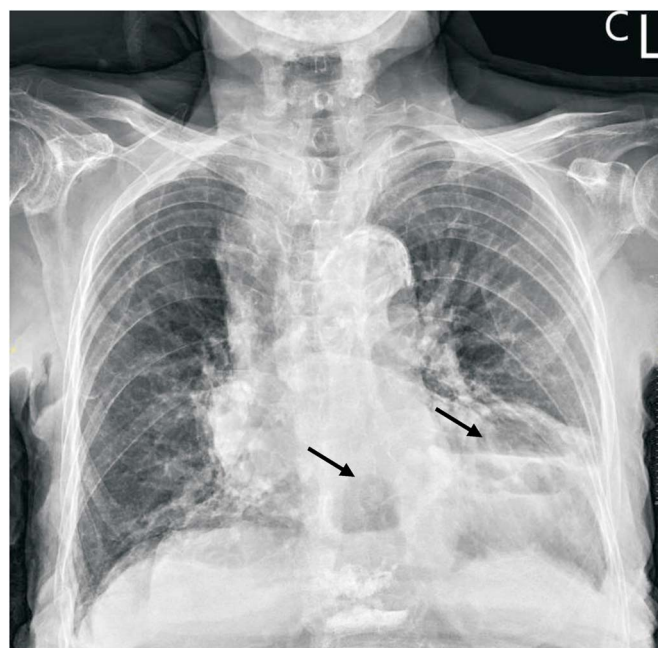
Posterior-anterior view of chest plain radiography. Arrows show multiple radiolucencies and an air-fluid level appearance superposed with the cardiac contour.
